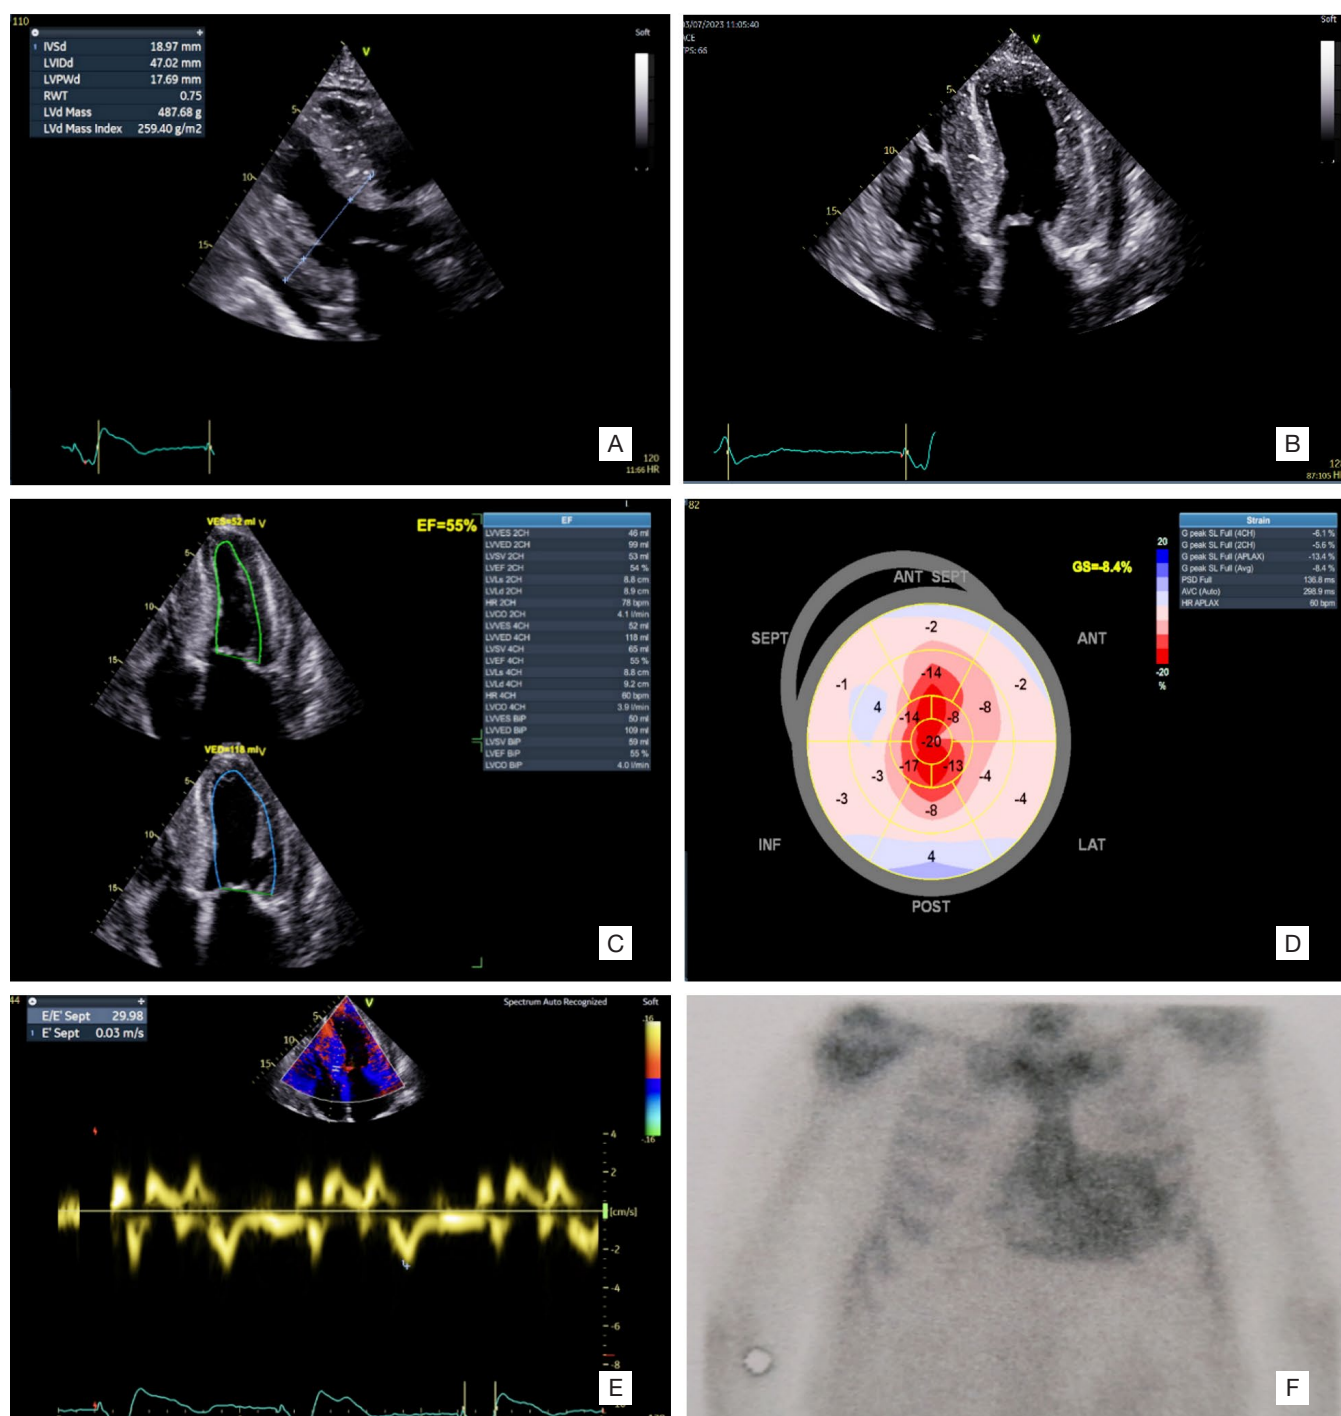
(A and B) TTE revealed severe thickness of the ventricular walls, with “granular sparkling”. (C) Preserved global left ventricular ejection fraction (biplane LVEF=55%). (D) Myocardial deformation analysis showed a basal-to-apical gradient (“apical sparing”) and decrease in global longitudinal strain (GLS=-8.4%) (E) Left ventricular diastolic measurements were abnormal, demonstrating diastolic dysfunction with elevated filling pressures (E/e’ septal=29.98) (F) ^{99m}Tc diphosphonate scintigraphy confirmed ATTR.
